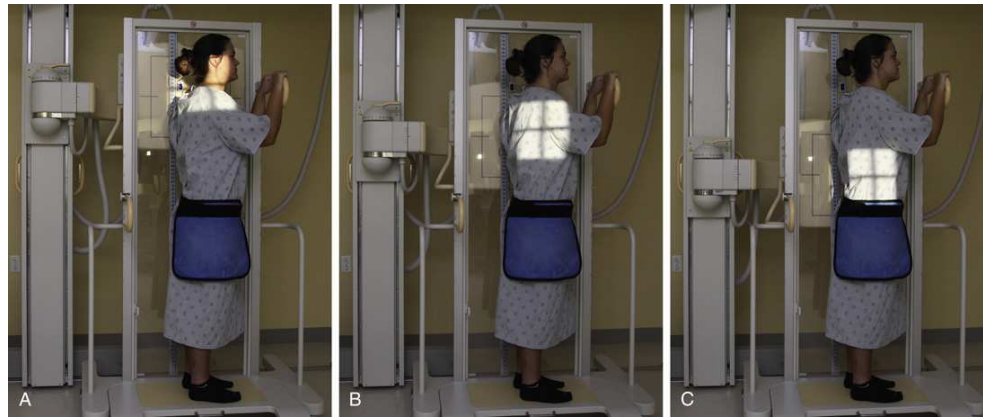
Standing full-spine radiography for evaluation of scoliosis. (A) Lateral projection to include the cervical spine. (B) Lateral projection to include the thoracic spine. (C) Lateral projection to include the lumbar spine and sacroiliac joints.
